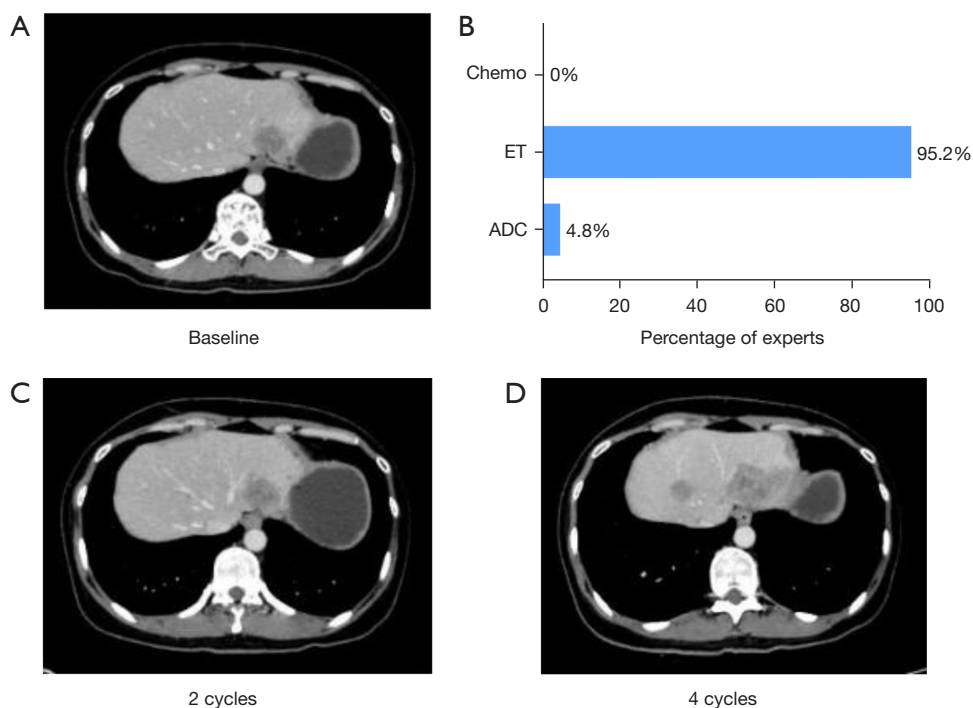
CT scan during the first-line treatment and expert opinions for therapy recommendation. (A) CT scan of liver metastases in baseline detection. (B) Expert opinions for therapy selection. (C,D) CT scan of liver metastases in the 2 cycle (C) and 4 cycle (D) of the first-line treatment. Chemo, chemotherapy; ET, endocrine therapy; ADC, antibody-drug conjugate; CT, computed tomography.
